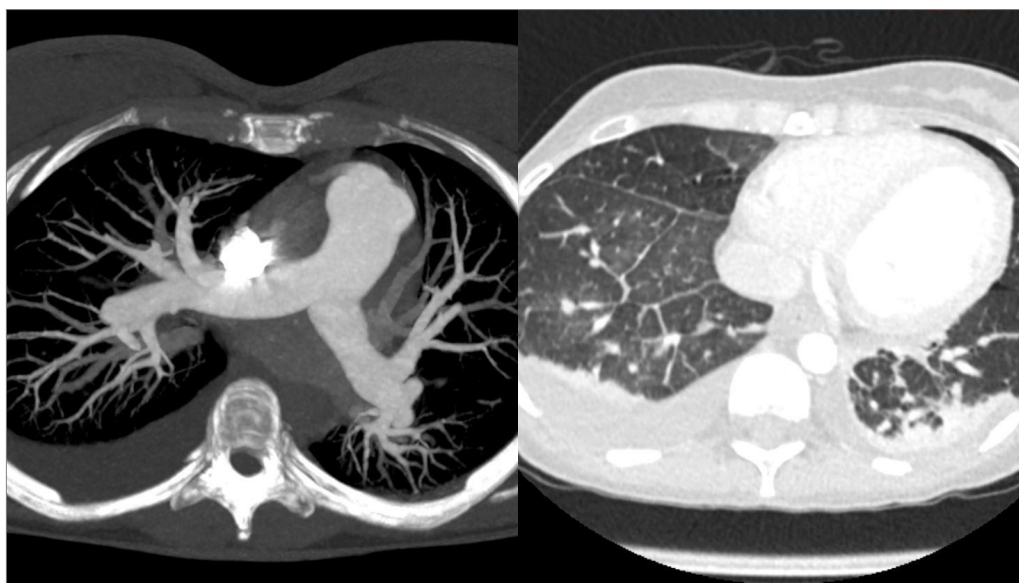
Chest CT of a 36-year-old woman with peripartum cardiomyopathy at admission, showing cardiomegaly with pulmonary edema and bilateral pleural effusion, without signs of PE
